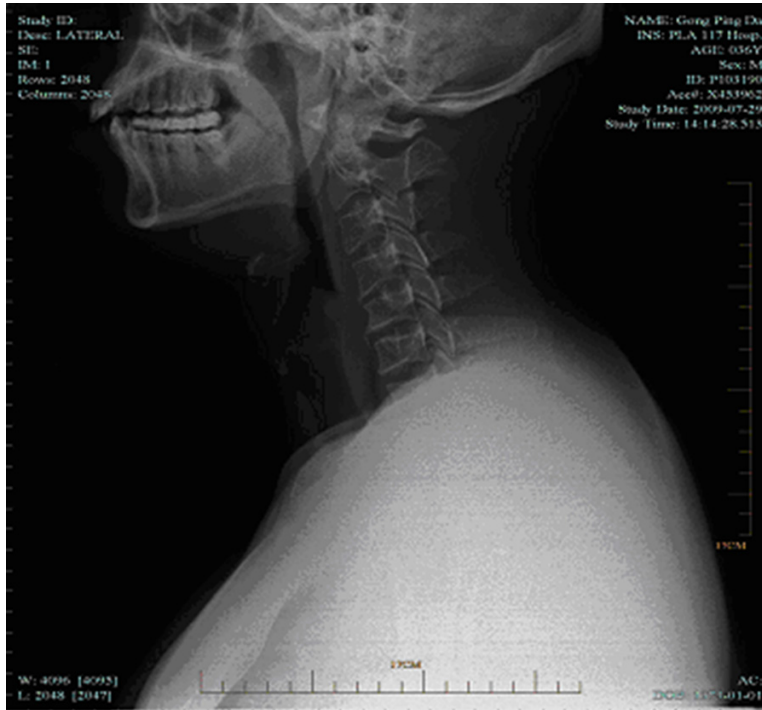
A lateral plain radiograph of cervical spine on admission.
